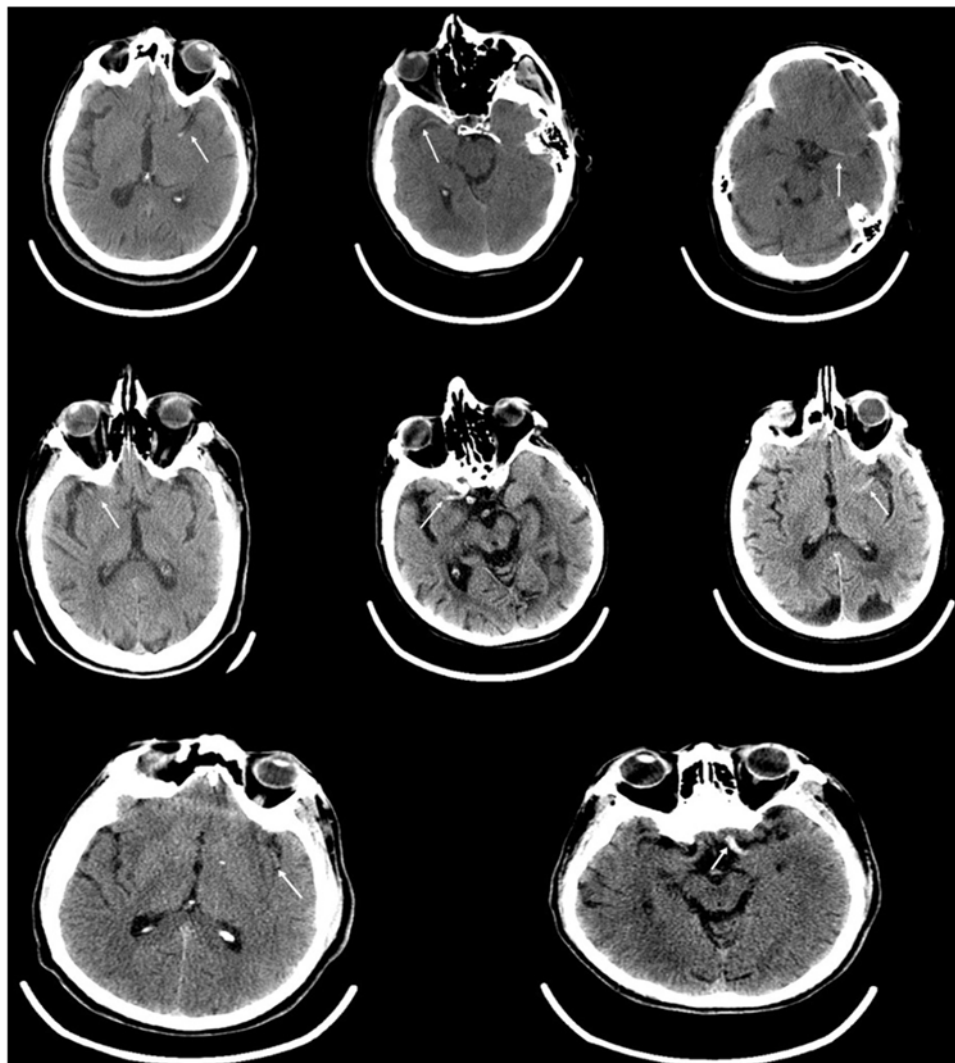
CT head images showing hyperdense vessel sign in DTAS patients.
